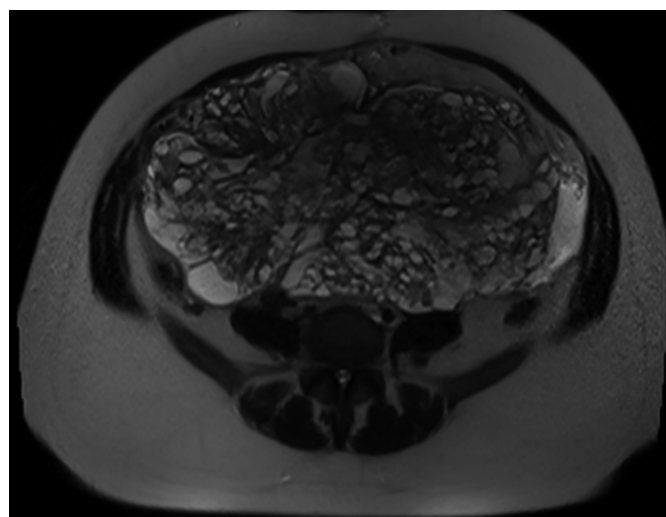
MRI showing rapid progression of the mass and new peritoneal implants during the chemotherapy.
